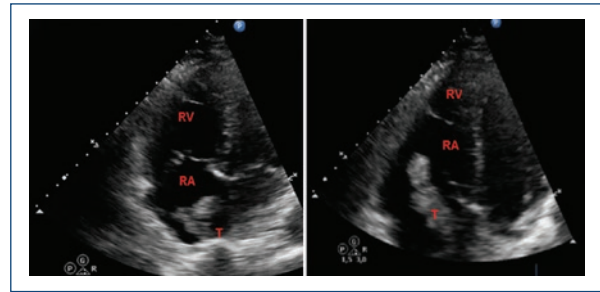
Transthoracic echocardiogram: RV: right ventricle; RA: right atrium; T: thrombus in transit.
